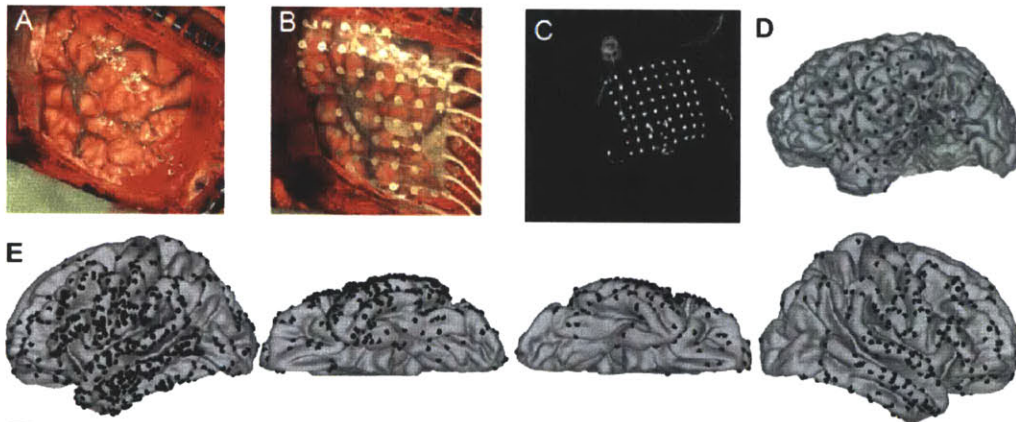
Intraoperative photographs, post-operative CT, and 3D registration of electrode coordinates on the cortical surface.
